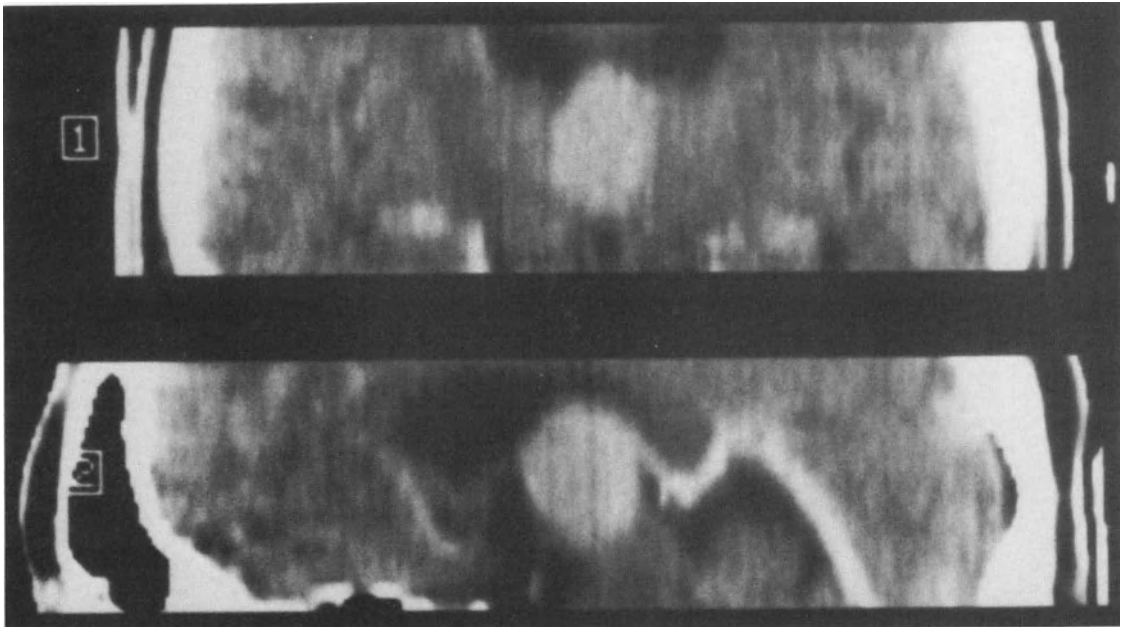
CT multiplanar reformatted image of a colloid cyst of the third ventricle obtained at the time of stereotactic aspiration. Volume estimation was performed also.
